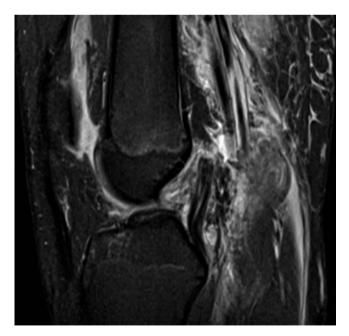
T2 Sagittal MRI of the right knee, demonstrating an acutely injured PCL. The femoral origin of the PCL has been torn off (*white arrow*), and there is evidence of increased signal in the substance of the ligament (*yellow arrow*). *PCL* posterior cruciate ligament
